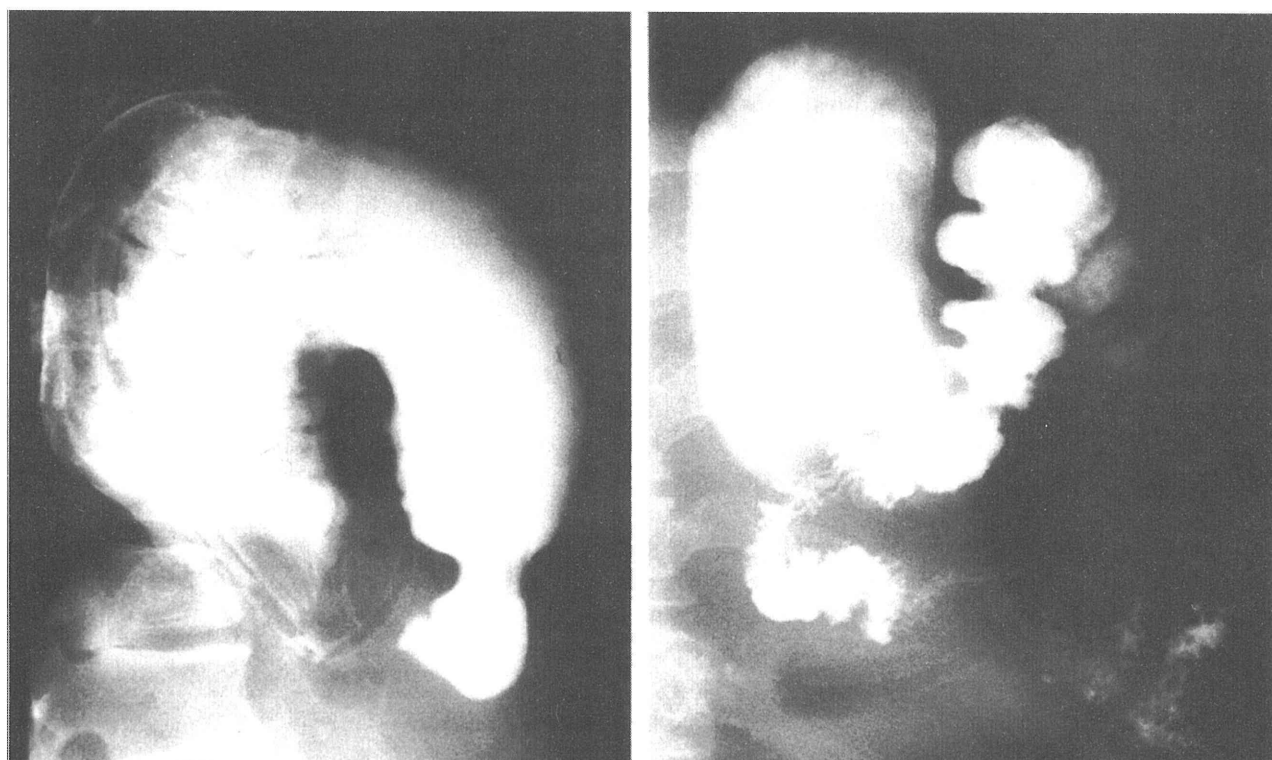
Upper gastrointestinal tract contrast radiography and retrograde colonography using gastrografin.
